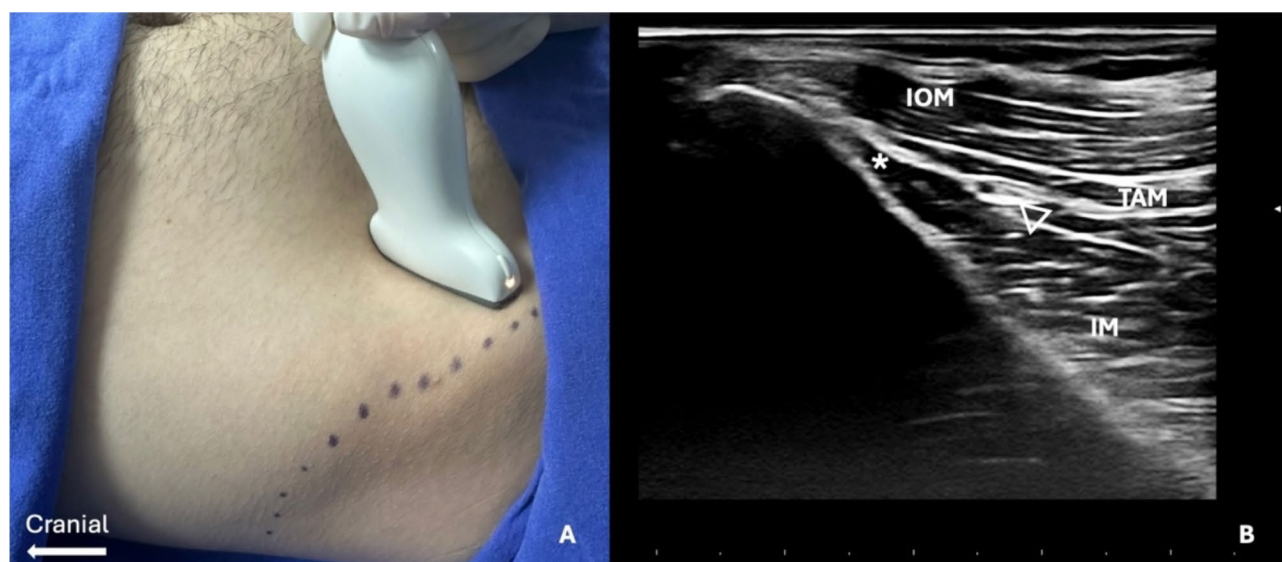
A: Probe position and B: ultrasound image of iliioinguinal-iliohypogastric nerve block technique. IOM: internal oblique muscle, TAM: transversus abdominis muscle, IM: iliacus muscle, *: ilioinguinal nerve, \blacktriangleleft deep circumflex iliac artery and iliohypogastric nerve
